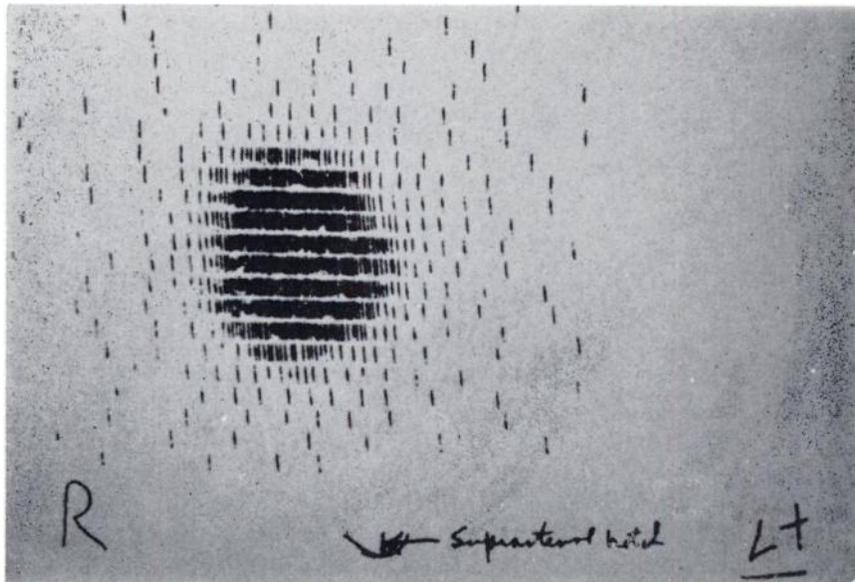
Case IV  $I^{131}$  scintigram prior to  $I^{131}$  therapy revealing an autonomous hyperfunctioning nodule.
